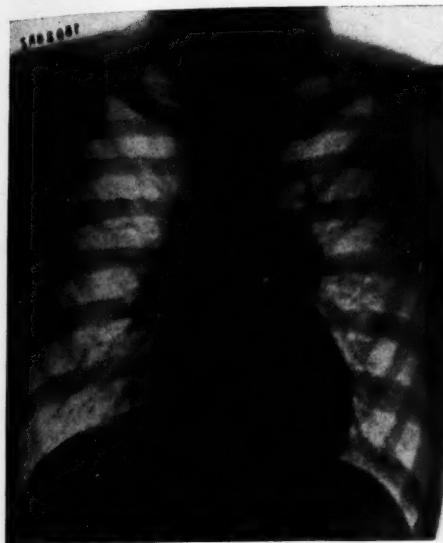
B. Chest radiograph of case shown in Figure 1 A. Note typical root changes.
